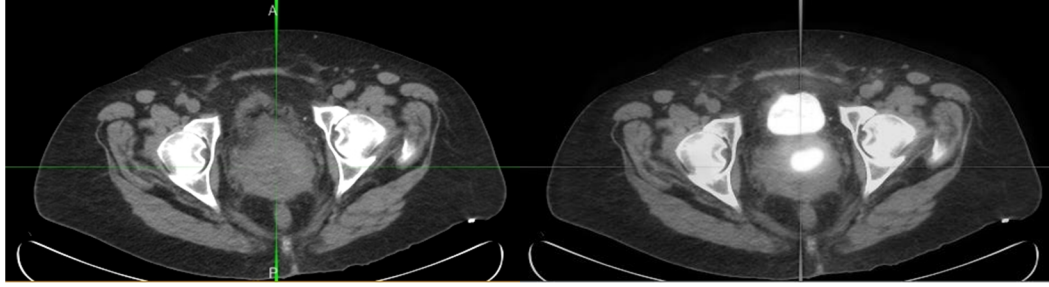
This figure shows the CT treatment image for the cervix (left), and the resulting image with an overlay of the PET image for plan design and optimization (right). We can clearly observe the PET tumor pockets (bright spots) inside the cervix.
